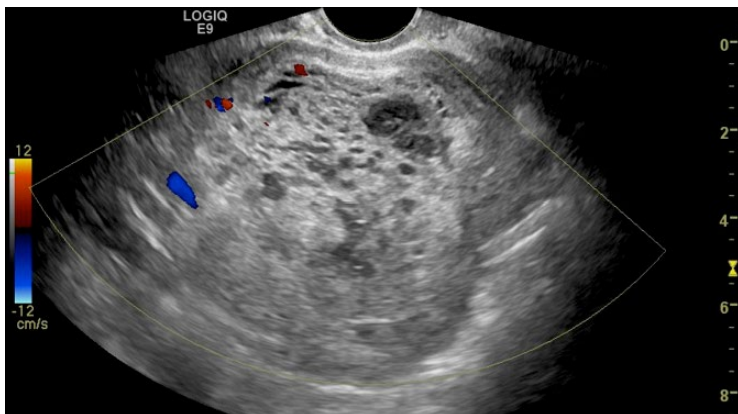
Ultrasound image demonstrating findings typical of a molar pregnancy.
